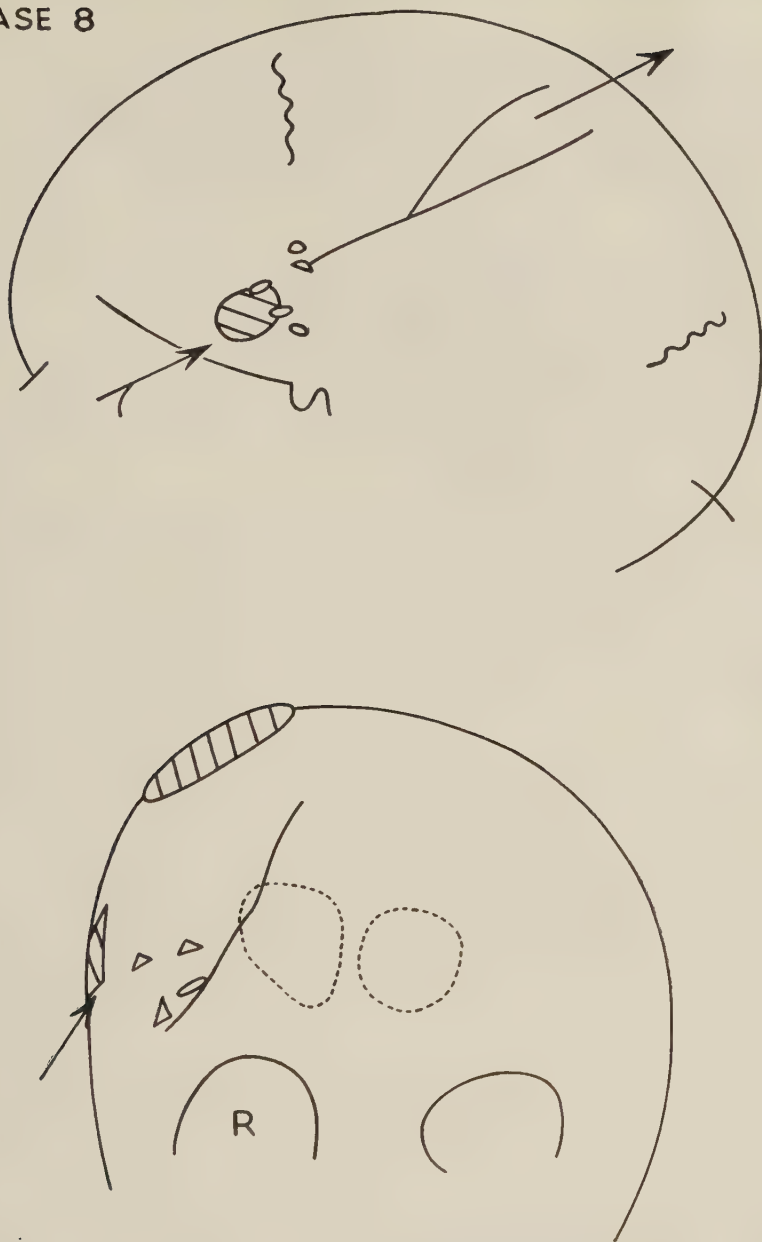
Tracings of skull radiographs in Case 8. Self-inflicted injury. Bullet entering right frontal lobe 3 cm. behind right eyebrow and passing through-and-through: exit right parietal region.
